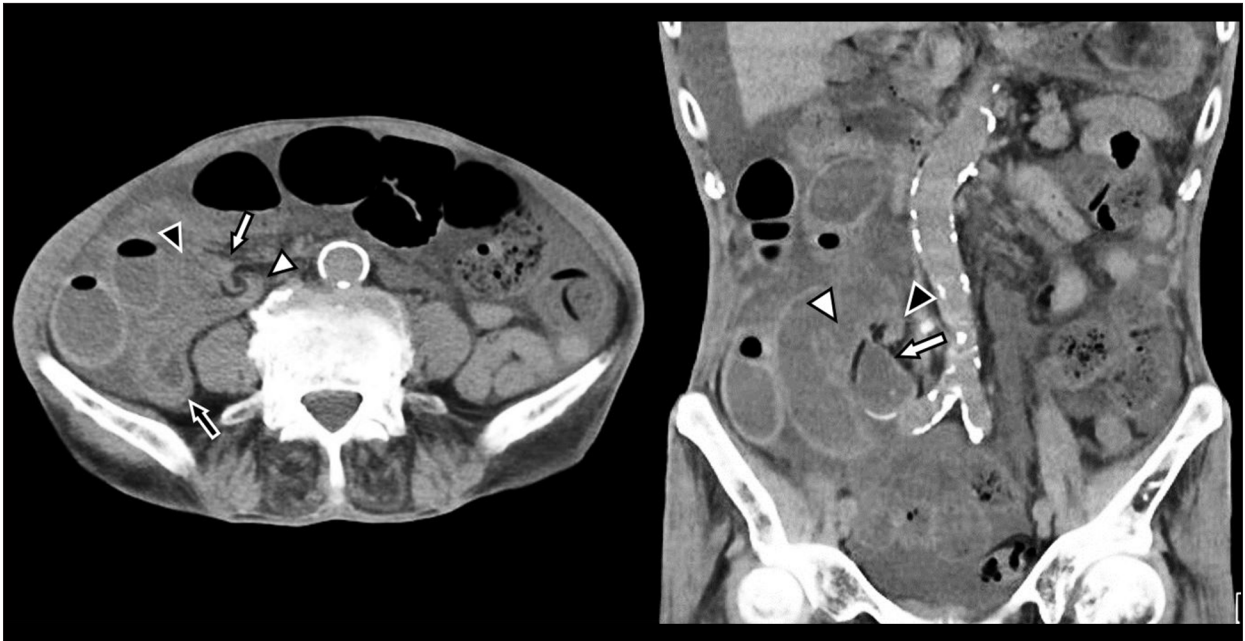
Computed tomography (CT) imaging in a case of low-grade appendiceal mucinous neoplasm (LAMN) presenting with strangulation ileus in a 92-year-old man. Transverse and sagittal abdominal computed tomography (CT) scans show dilatation of an obstructed small bowel loop and cord-like and dilated structures of the cecum (white arrow) and strangulation of the ileum (black arrow).
